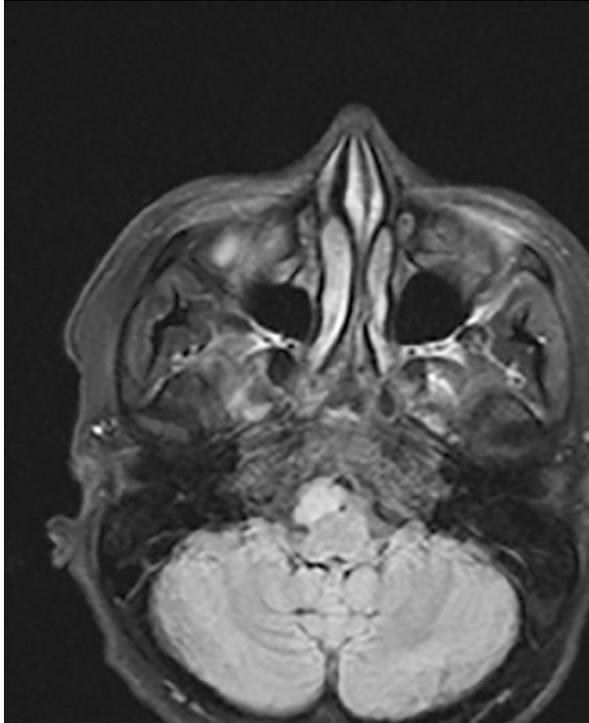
Preoperative head MRI of a 48-year old female patient with right abducens nerve palsy and a neurenteric preoptine cyst. The cyst was removed entirely and the abducens nerve palsy normalized.
